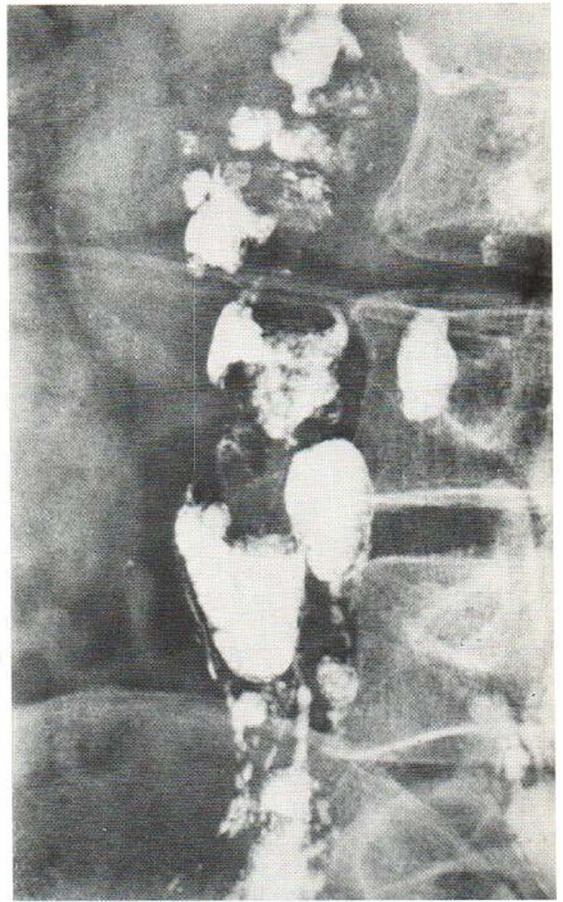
Markedly enlarged retroperitoneal lymph nodes with large filling defects. The patient had X-ray evidence of previous lung tuberculosis. The connection of the lymphographic findings with the panniculitis of the legs remained unproved. The disorder was classified as NDP.
